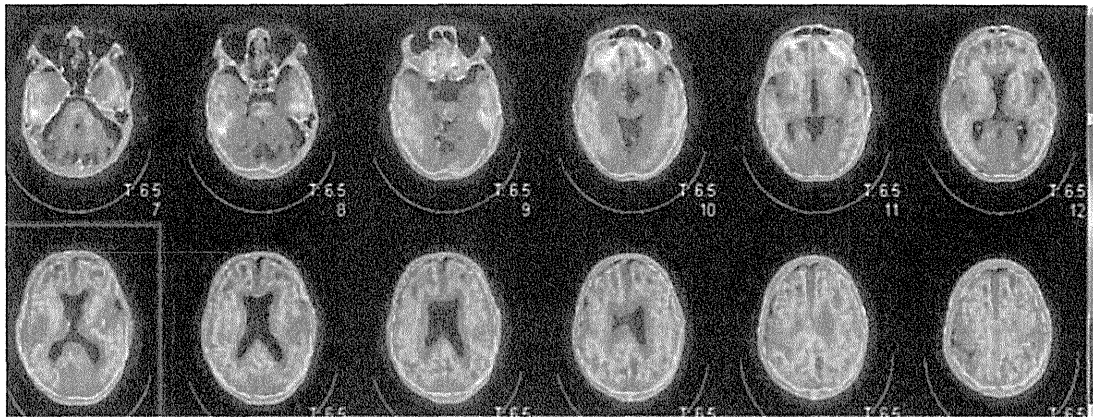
Increased ^{11}C -PIB uptake indicating amyloid deposits was noted in the bilateral precuneus, the lateral aspect of both parietotemporal lobes, the frontal cortex, and the ventral striatum. In contrast, no brain uptake was noted on $^{99\text{m}}\text{Tc}$ -aprotinin SPECT images; however, this was an expected finding because $^{99\text{m}}\text{Tc}$ -aprotinin does not cross the blood-brain barrier.⁴ Amyloidosis is a disease caused by extracellular deposition of the amyloid protein and can lead to organ dysfunction and death. Because amyloid deposition can vary in various tissues, the clinical presentation can similarly vary.^{10,11} For example, the manifestation of cardiac amyloidosis can vary from myocardial infiltration with amyloid cardiomyopathy to small vessel involvement with cardiac ischemia. In this situation, noninvasive imaging techniques play a significant role in early diagnosis, enabling early interventions and subsequent disease monitoring. However, as our results indicate, selective use of radiopharmaceuticals is also important and should be based on clinical symptoms.
